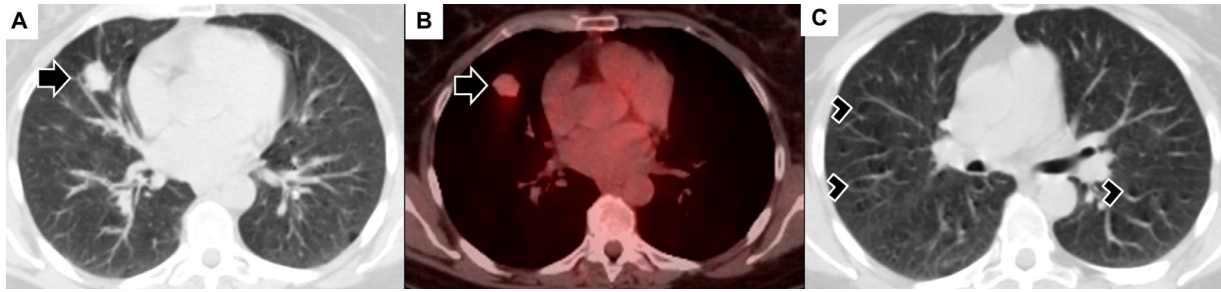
Imaging findings in a 56-year-old woman with pulmonary light chain deposition disease and MALT lymphoma (case 1). (A) Axial slice from a low dose non-contrast chest CT obtained as part of an FDG PET/CT examination demonstrates a dominant 2.1 × 2.4 × 1.2 cm solid lobulated pulmonary nodule in the right middle lobe (arrow) which showed mild FDG avidity (B). (C) Additional axial slice from the same low dose non-contrast chest CT demonstrates multiple pulmonary cysts in a slightly peripheral predominant distribution in both lungs (arrowheads).
